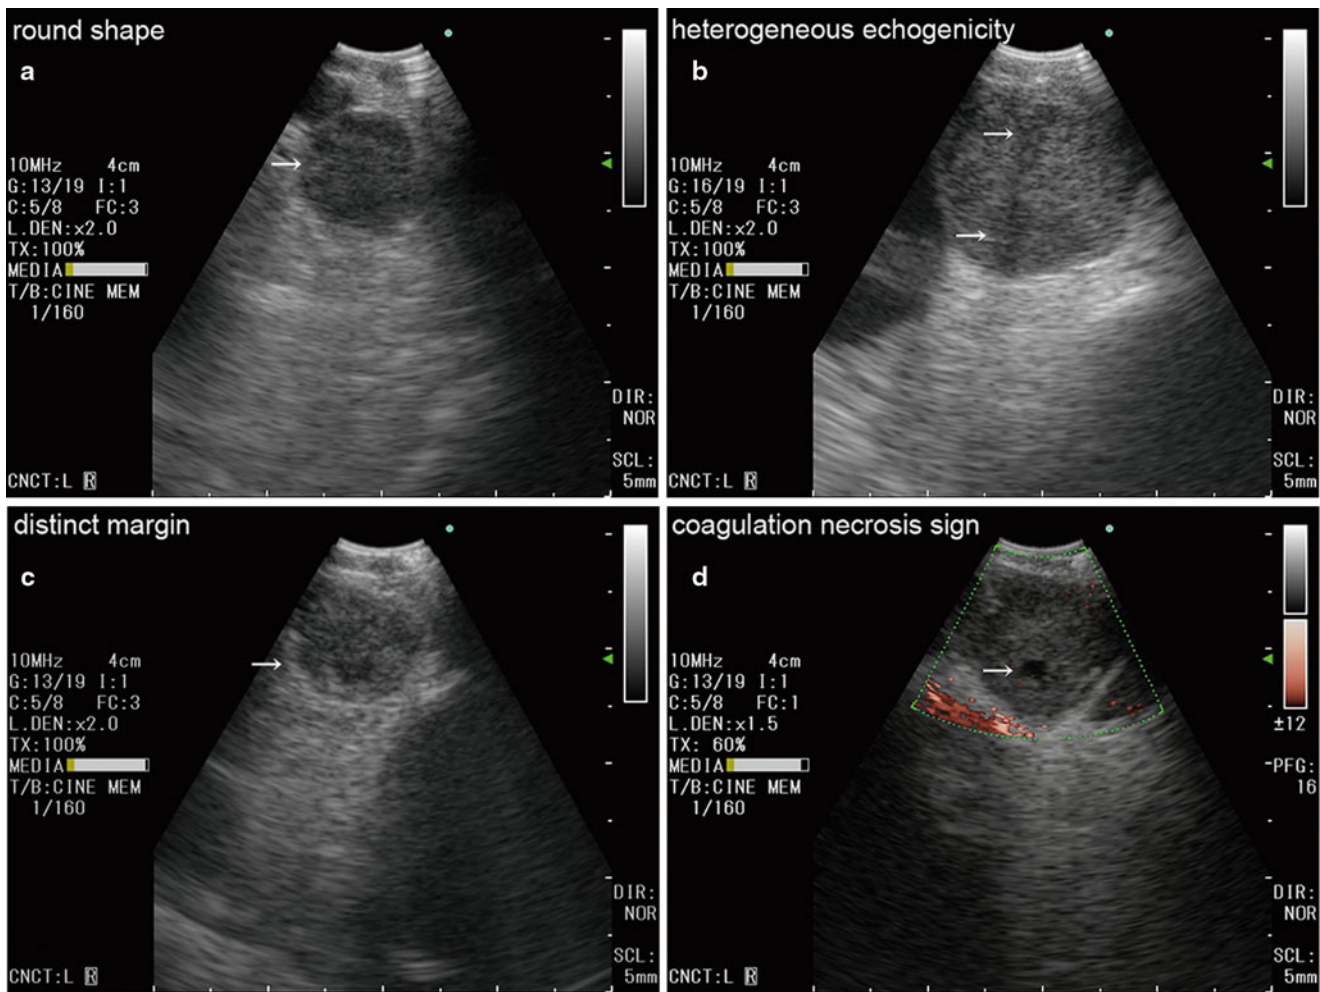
Sonographic features of lymph nodes during endobronchial ultrasound. Lymph nodes with the following characters: round shape (a), heterogeneous echogenicity (b), distinct margin (c), and presence
